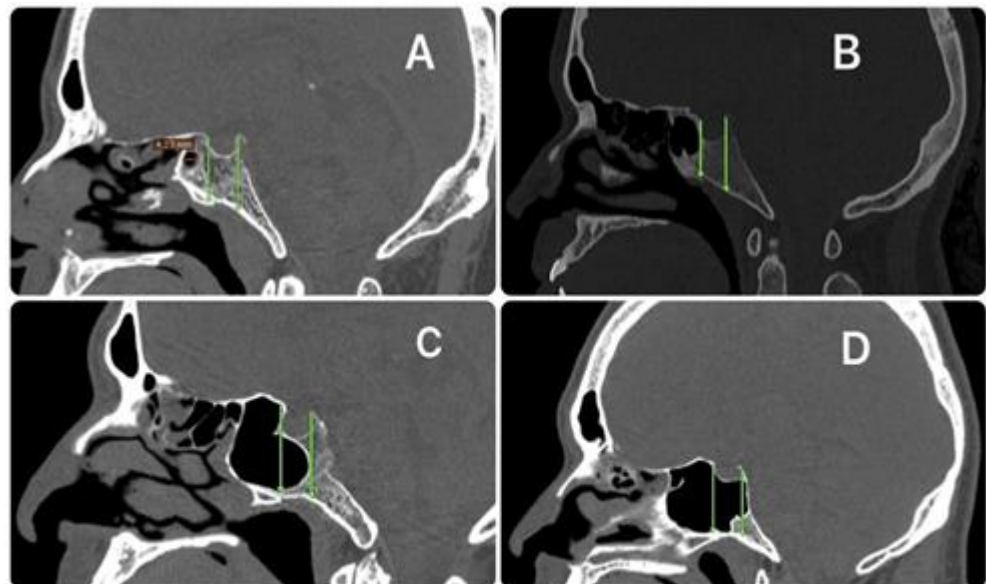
Classification of the posterior extent of sellar pneumatization; Midsagittal CT images revealing types of sphenoid pneumatization. A: Conchal type. B: Presellar type. C: Sellar. D: Postsellar.
